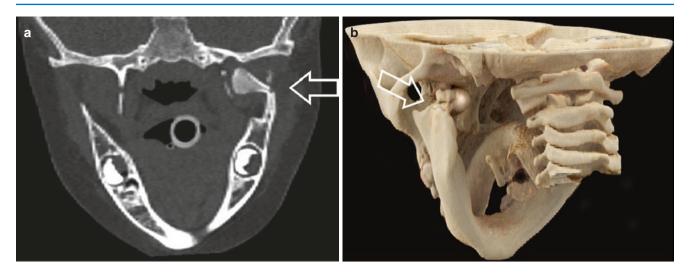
Unilateral condylar fracture in a child who fell forward on her chin during potty training. Arrows indicate the fracture in coronal CT (a) and 3D rendering (b)
